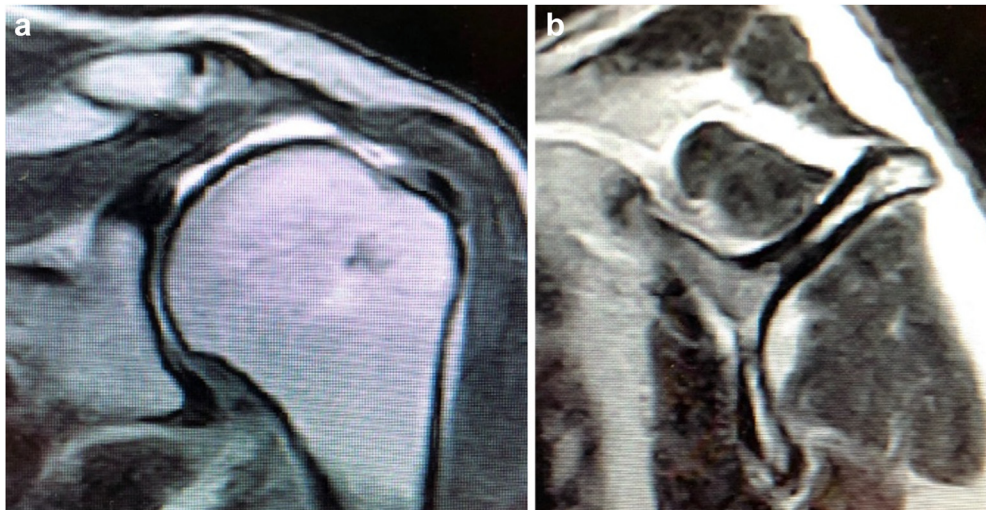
(a) Preoperative coronal and (b) sagittal T2 MRI showing a three-centimeter retracted rotator cuff tear and Goutallier stage 0/I supraspinatus. MRI, magnetic resonance imaging.
